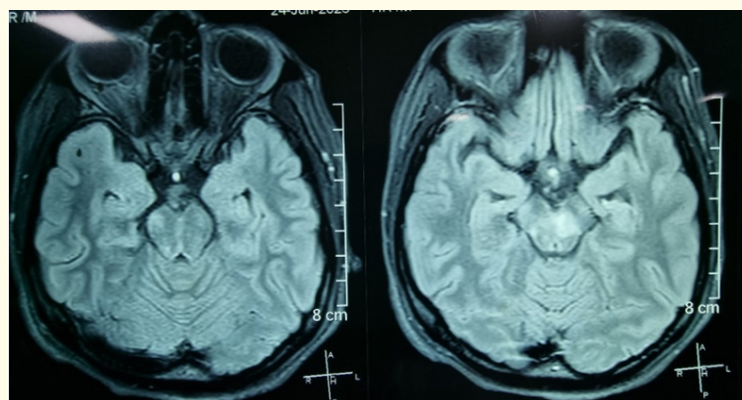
FLAIR hyperintensities in midbrain too.
